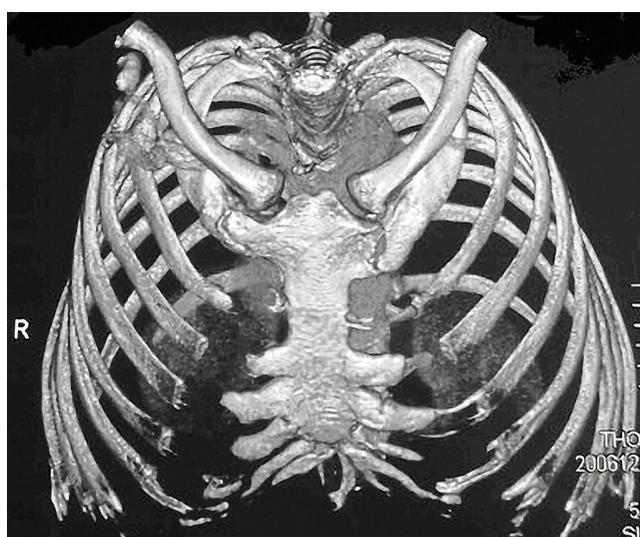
3D CT of thoracic bones, soft tissue density and lytic lesions were seen bilaterally in 1st sternocostal joints and in right side of xiphoid.
